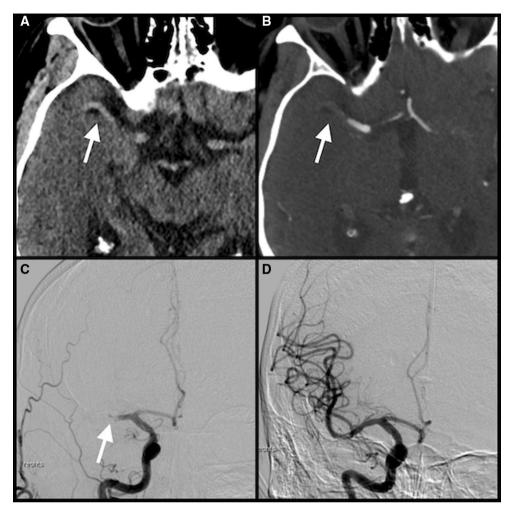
Patient with an MCA occlusion (proximal M1 segment). Initial non-contrast CT with a large hyperdense clot (*arrow*) (A); CT angiogram showing the occlusion with contrast sparing on the clot
